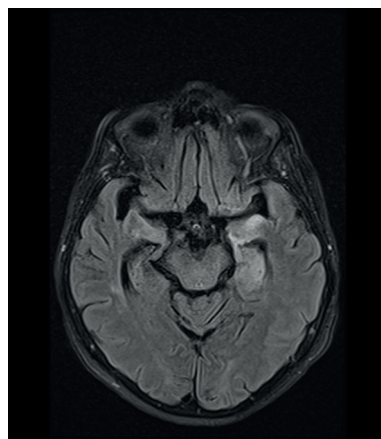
Panel B. Brain MRI
